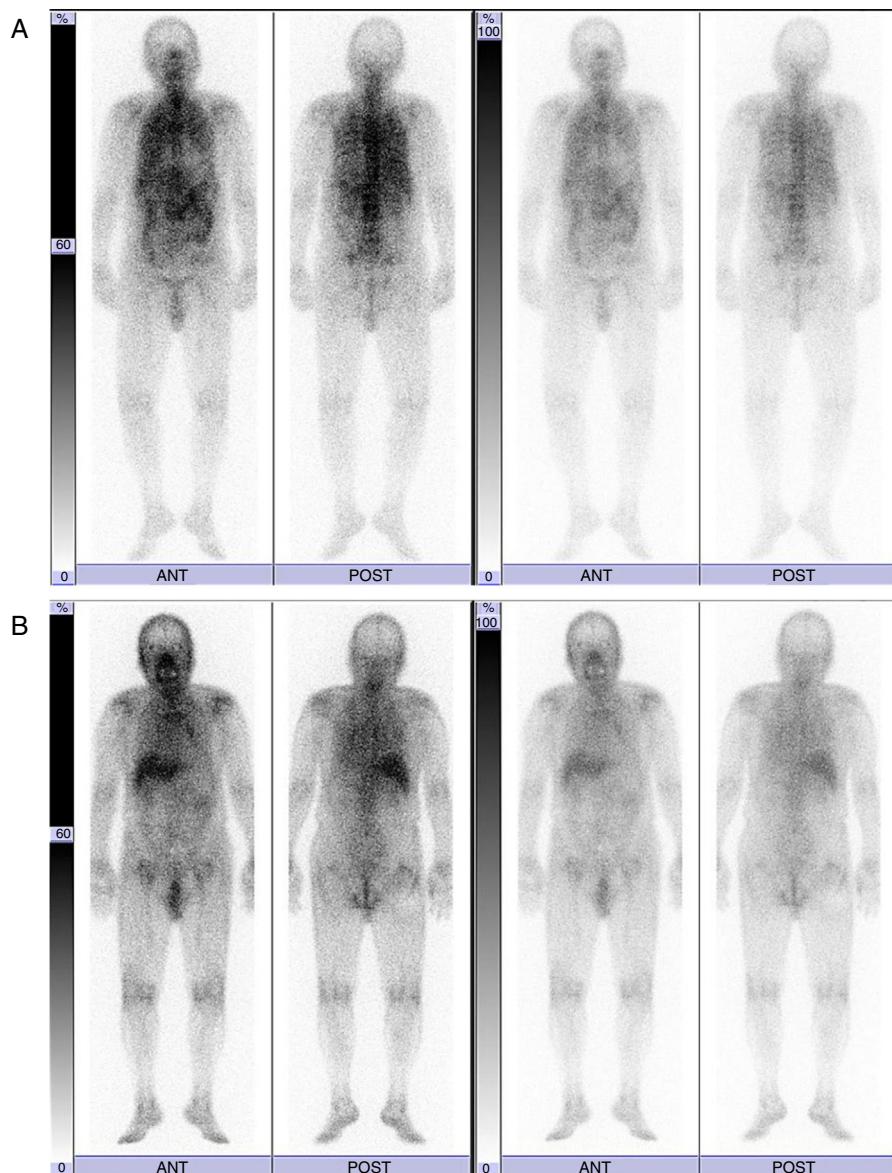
^{67}Ga scintigraphy findings before (A) and 3 months after the administration of antituberculosis drugs (B).
